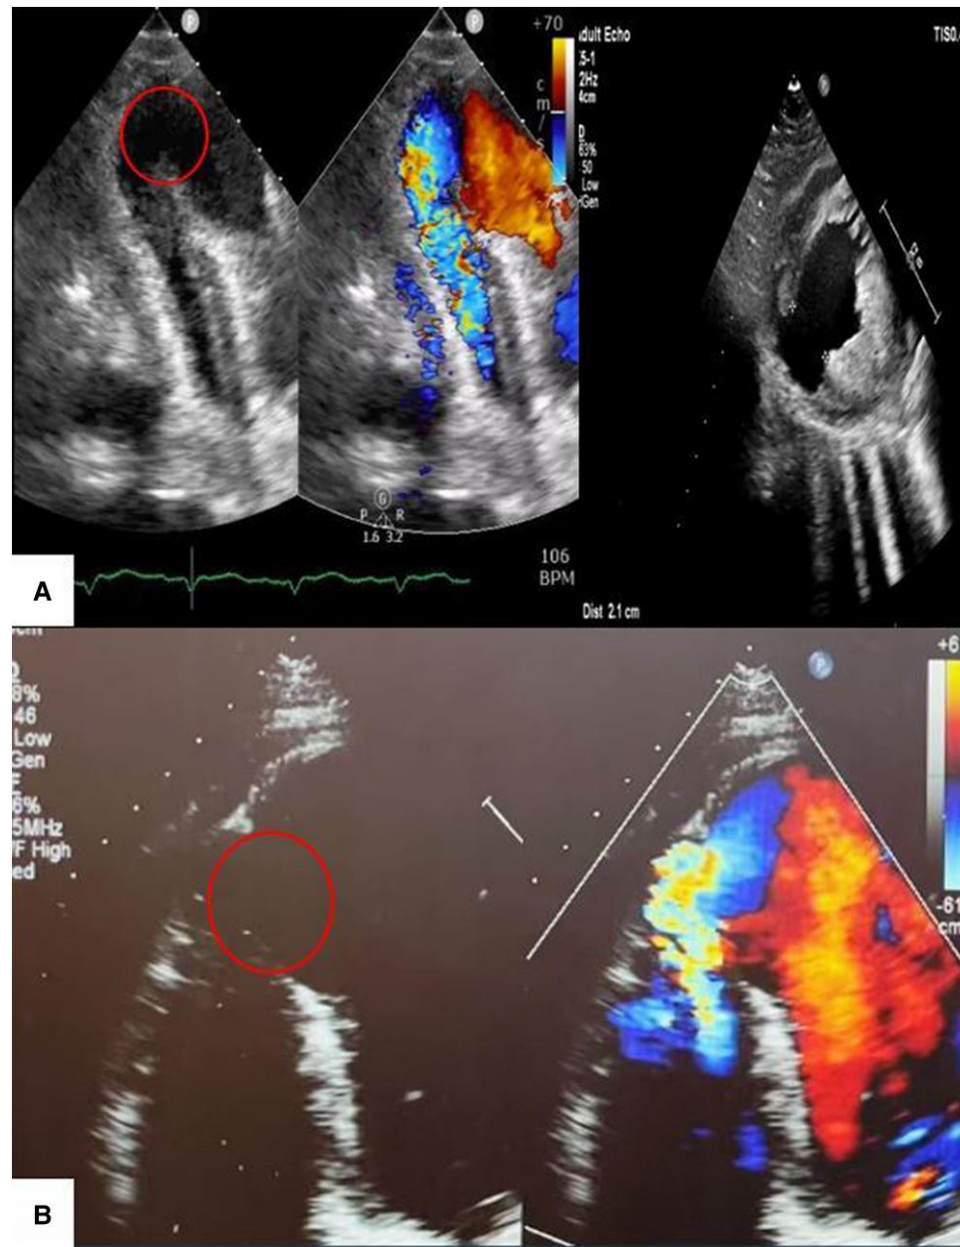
Preoperative transthoracic echocardiography. (A) Patient 1 apical four-chamber with RV focused and parasternal short-axis views demonstrating apical post-infarction ventricular septal defect (PIVSD) (circled). (B) Patient 2 apical four-chamber view demonstrating PIVSD (circled).
